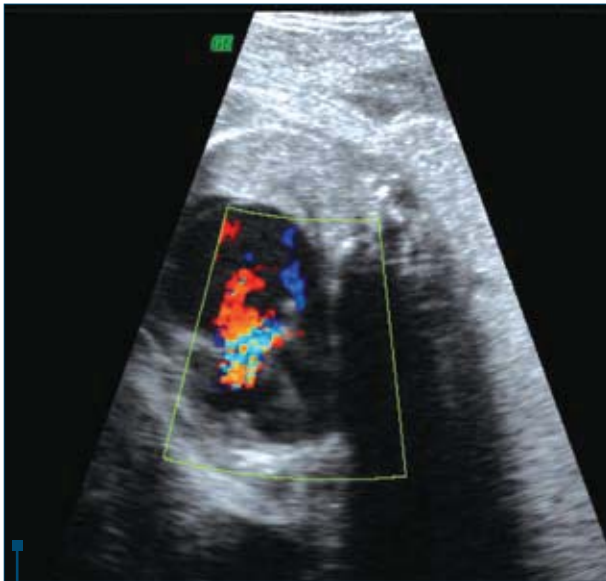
Display of tricuspid valve in the 4 rooms section in fetus, with CFM Doppler
